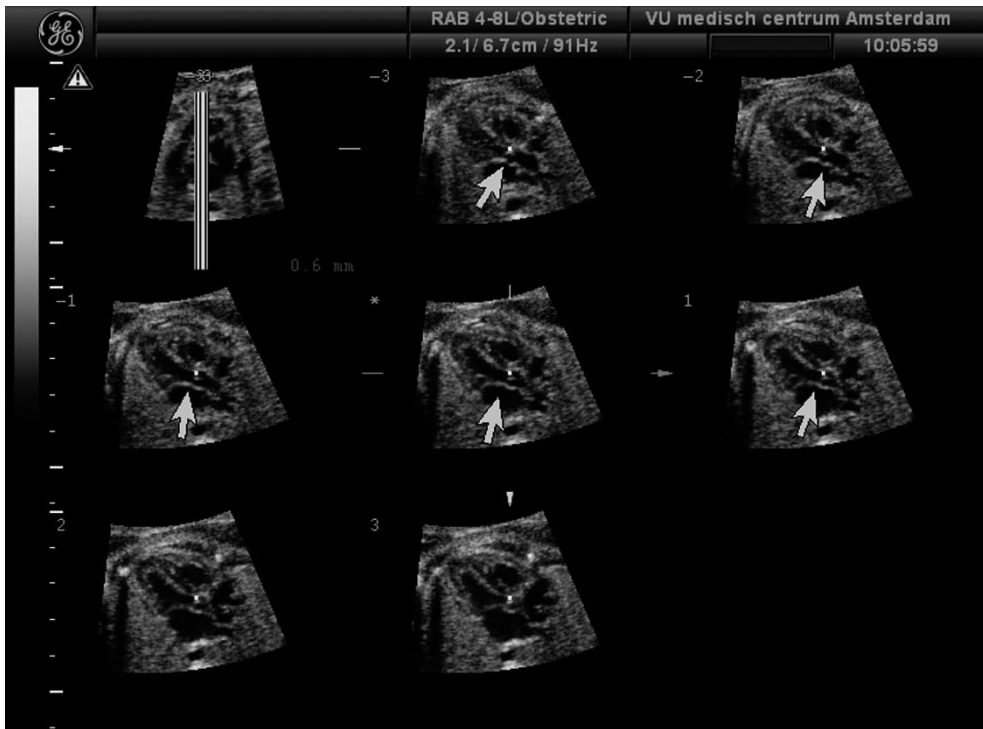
Sonography-Based Volume Computer-Aided Diagnosis display of cardiac plane 1 (LVOT, and aorta) showing clear continuity between the aorta and the ventricular septum on a longitudinal view of the outflow tract. The LVOT is clearly visible in several TUI planes in this volume (arrows).
